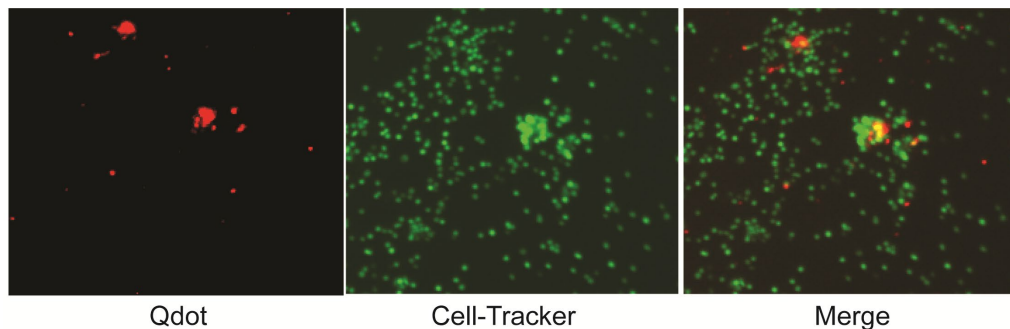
Direct comparison of MO doubled-labeled with Q-Tracker (Qdot) and CellTracker CMFDA (CT) demonstrates that CT is more effective at labeling MO.
